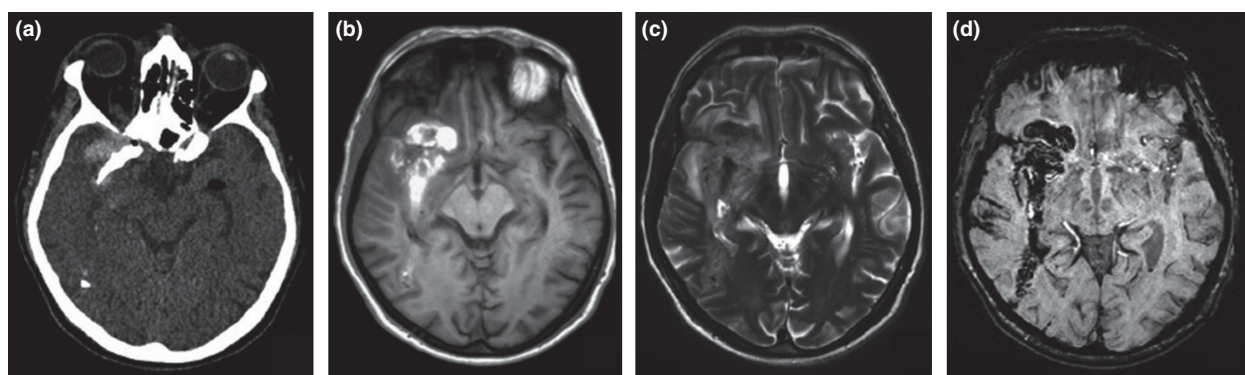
Wooden penetrating foreign body, (a) Axial non-contrast CT; (b) Axial spin-echo T1-weighted MRI; (c) Axial fast-spin echo T2-weighted MR and (d) SWI imaging of the same patient.³⁹ A wooden object has passed through the orbit, into the parieto-occipital region, abutting the inner aspect of the skull. Note the application of SWI imaging to demonstrate the tract. MRI, magnetic resonance imaging; SWI, susceptibility-weighted imaging.
